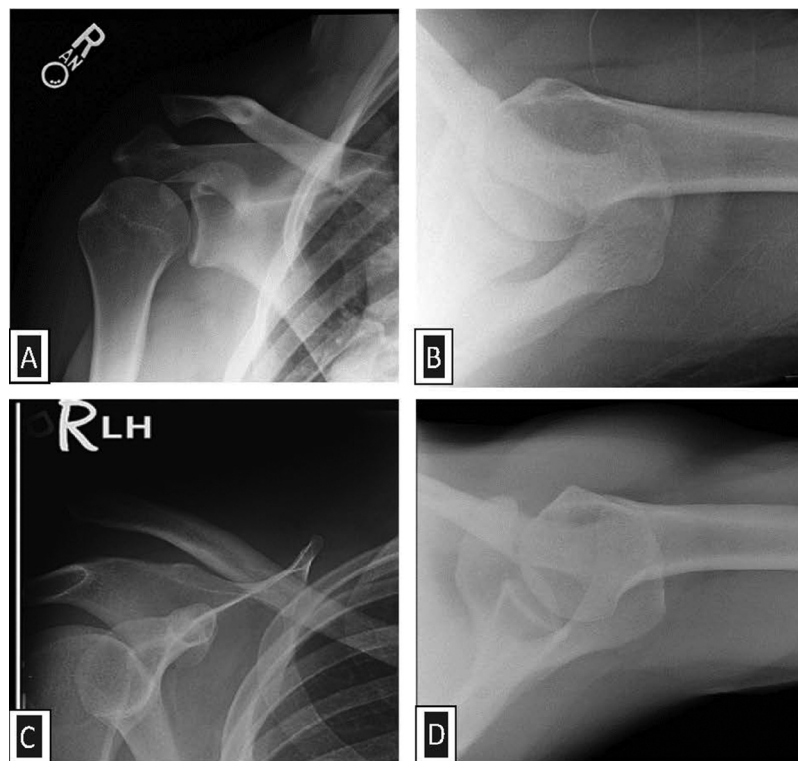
Anteroposterior (A) and axial (B) radiographs showing a Rockwood type III dislocation. Anteroposterior (C) and axial (D) radiographs showing a Rockwood type V dislocation.
